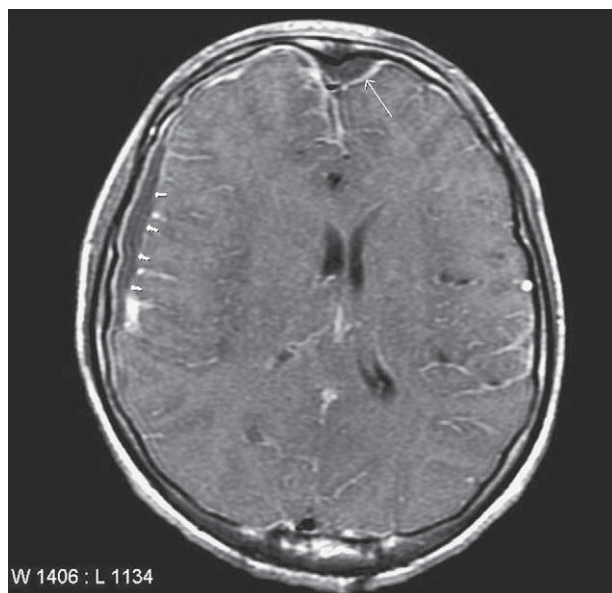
T1-weighted brain magnetic resonance imaging after gadolinium injection shows diffuse leptomeningeal enhancement bilaterally over the cerebral hemispheres with a faint high signal, suggesting a fluid collection with ring enhancement at the right frontoparietal subdural space (small arrows) and left medial-frontal epidural space (large arrow).
